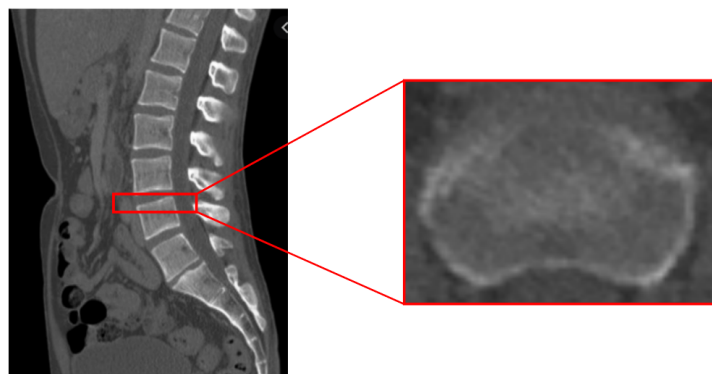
An example of a difficult region to accurately segment. Segmentation of the vertebrae is challenging due to the partial volume effect and the slice angle through each vertebra. An example of a typical vertebra in a CT scan – it is unclear where the upper segmentation boundary should be in this case due to the small angle difference between the surface of the vertebra and the CT slice. The CT data is from the Addenbrooke's Hospital CT Data Collection.
